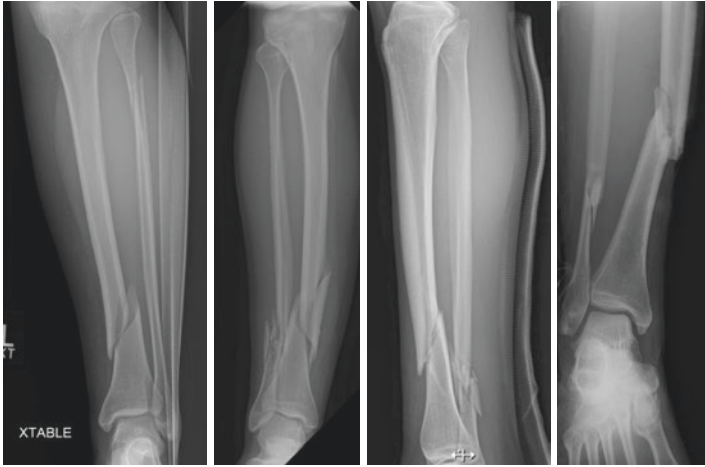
Representative radiographs of adult tibial shaft fractures
